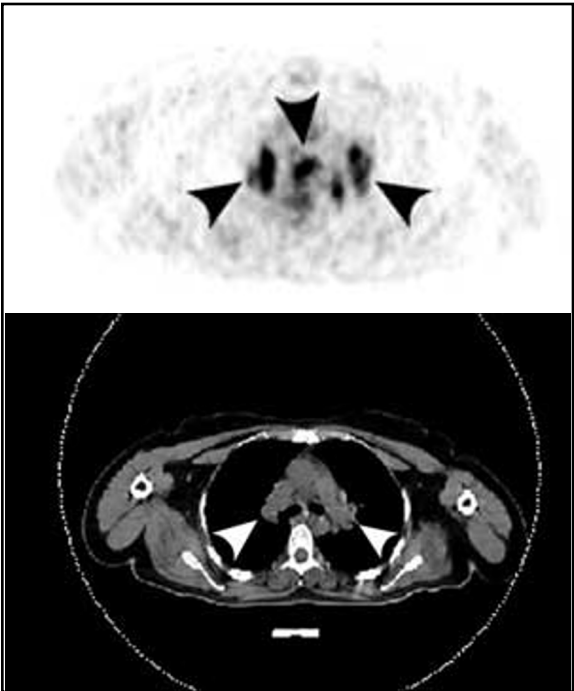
50-year-old woman with ovarian sarcoidosis. PET/CT scan demonstrates bilateral hilar and subcarinal enlarged lymph nodes (arrowheads) with increased FDG uptake.
